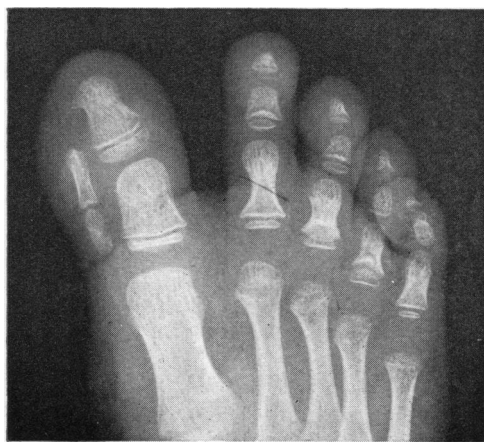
Case 1, x-ray film of right foot.
